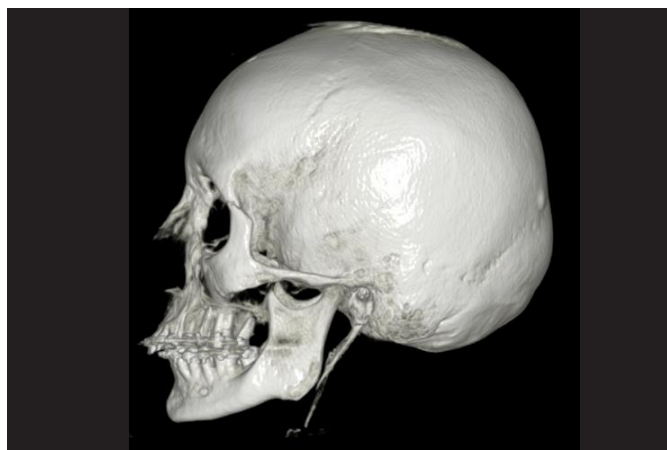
CBCT image of a SP measuring 69 mm.
